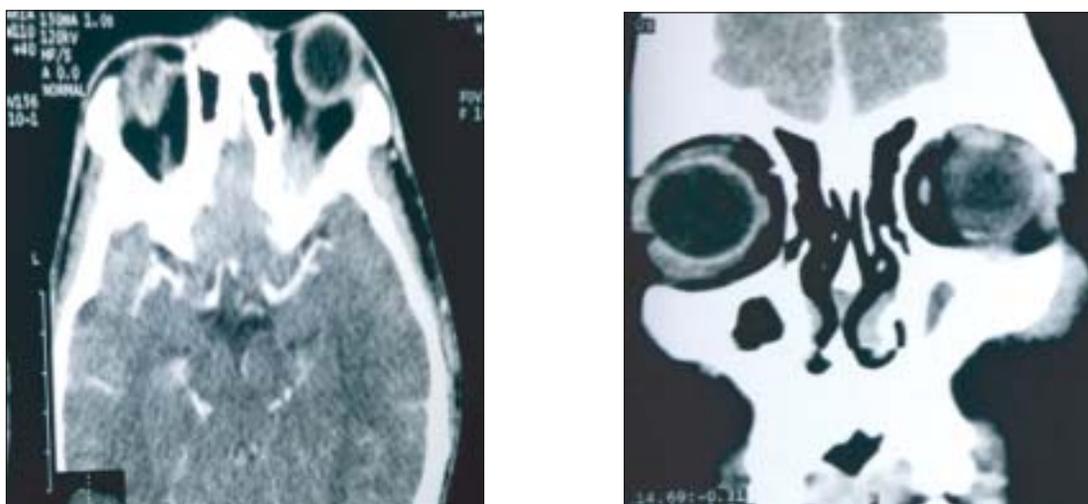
CT scan of the orbit showing soft tissue mass in left orbit.
